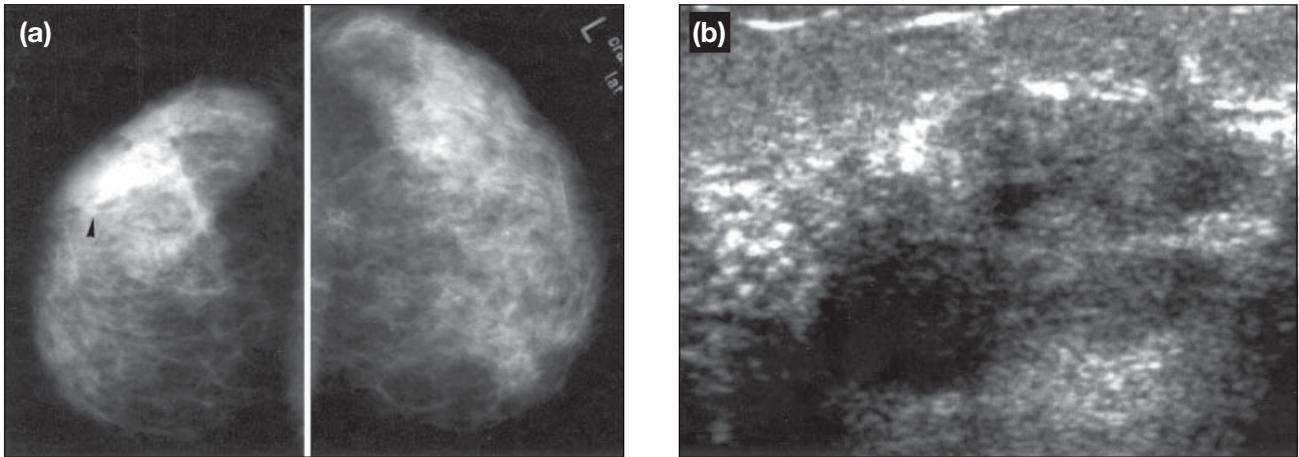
Granulomatous mastitis. (a) Cranio-caudal views of both breasts of a 28-year-old postpartum woman show asymmetry of the breasts with increased density over the lateral aspect of the right breast (small black arrowhead). Typically the asymmetrical density on mammogram seldom involves the retroareolar region. (b) Ultrasound study shows an irregular hypoechoic mass with ill-defined outline and mild posterior shadowing, suspicious of malignancy. Core biopsy confirmed the diagnosis of granulomatous mastitis.
